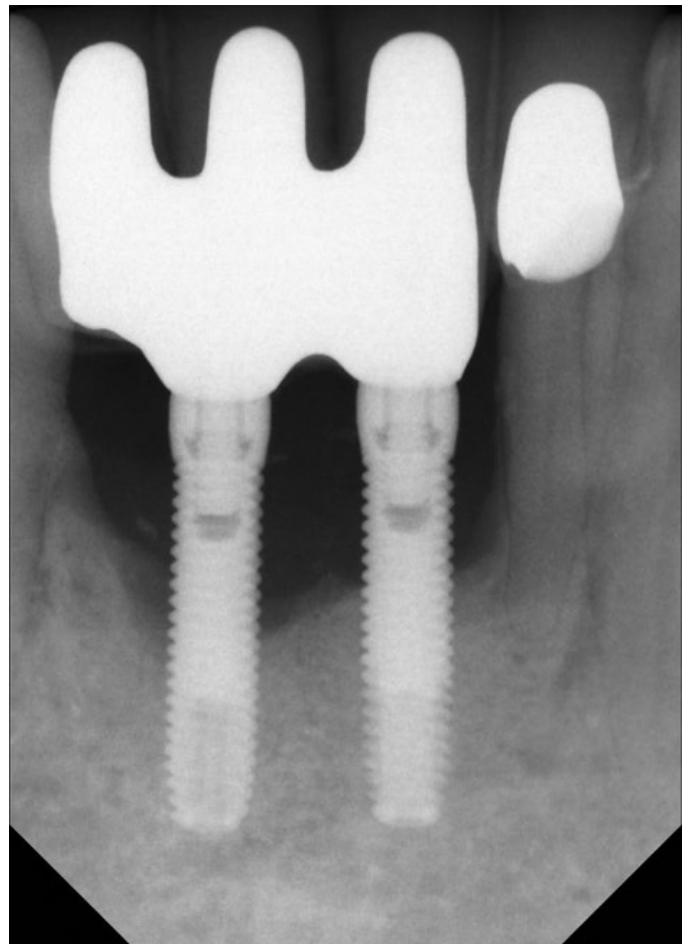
(D) At 6 months, the X-ray shows significant bone growth around the implant.
